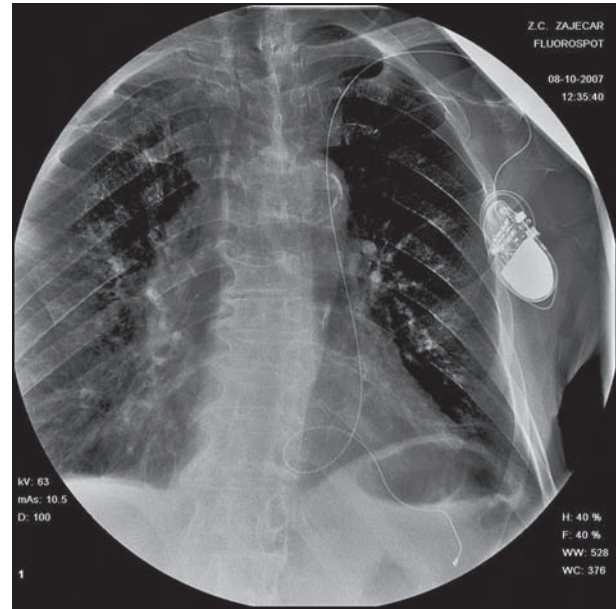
PA chest radiography: lead in coronary sinus and VVI pacemaker
